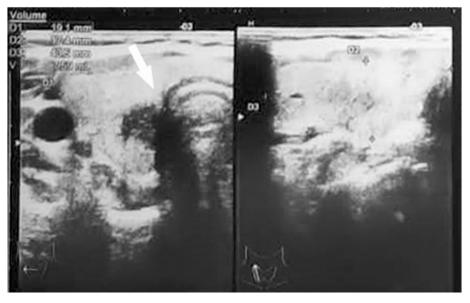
Ultrasound findings: hypoechoic 19 mm-nodule that seems indissociable from the trachea and cricoid (white arrow).
